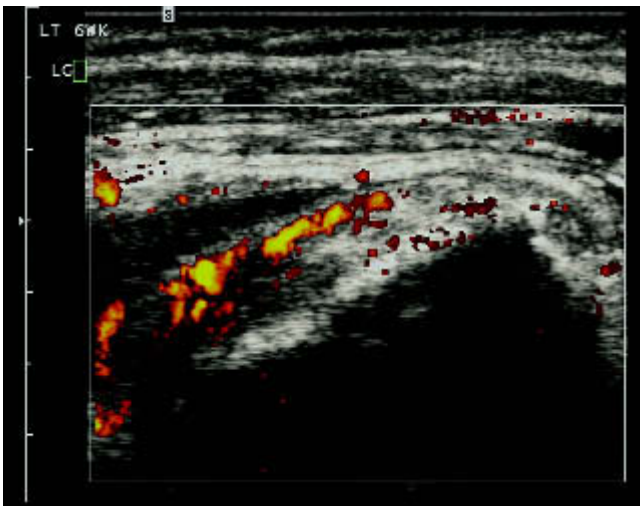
Power Doppler sonography depicting a robust arterial flow in an artery that is within a repaired tendon.
